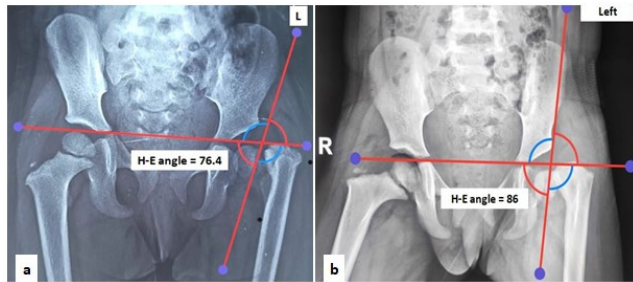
Serial radiographic progression of proximal femoral physis verticalization. Anteroposterior radiographs of the pelvis obtained over a three-month interval demonstrate progressive verticalization of the right proximal femoral physis. The calculated Hilgenreiner-Epiphyseal (H-E) angle increased from an initial 76.4° (left) to a highly unstable 86.0° (right), signifying severe instability and high risk for progressive coxa vara.
